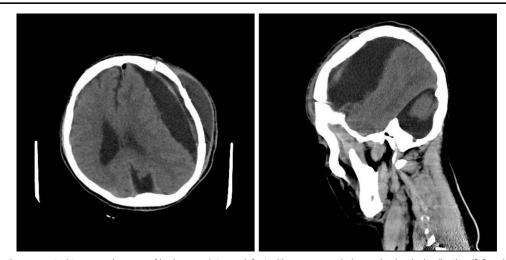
Postoperative computed tomography scan of brain—craniotomy defect with pneumocephalus and subgaleal collection (2.3 cm) in left fronto-parietal bone, crescentric hypodensity indicating subdural collection (2.3 cm) with compression effects on adjacent brain parenchyma, partial effacement of left lateral ventricle, and 1.4 cm midline shift towards the left side.
